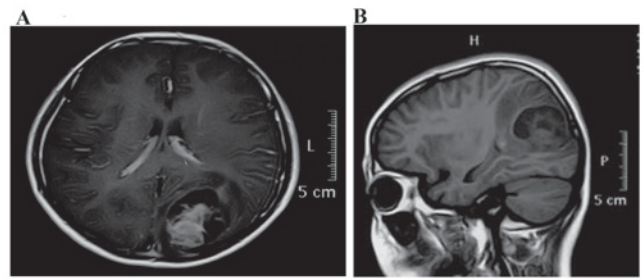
(A) Coronal and (B) sagittal T1-weighted MRI scans presenting a contrast-enhancing lesion (4.5x3 cm) in the left temporo-occipital region with focal cystic degeneration. MRI, magnetic resonance imaging.
